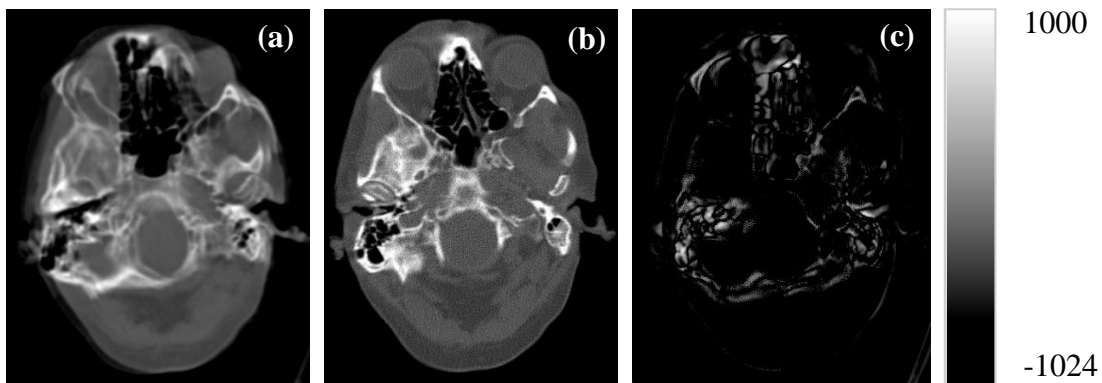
(a) CT image reconstructed by vendor software without motion-correction, (b) motion corrected reconstruction and ghost artifact removed after motion-correction, (c) absolute difference between a and b image.
